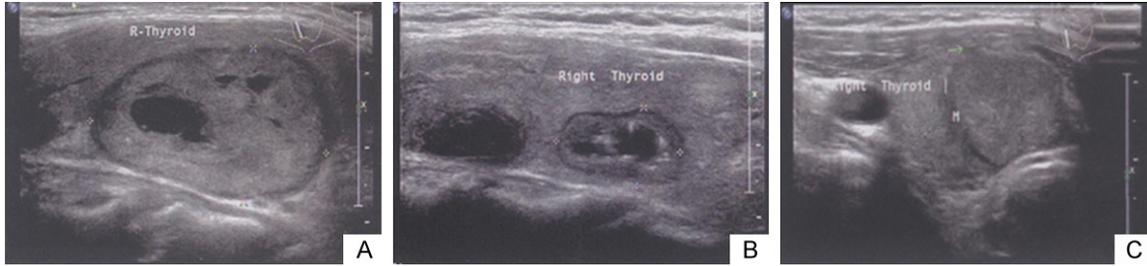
Conventional ultrasound images of the thyroid nodules. A. Halos with different thickness can be seen around the nodules; B. Punctate hyperecho was detected in nodules; C. Signs of thyroid carcinoma are displayed, and halos can be seen in the surrounding area.
